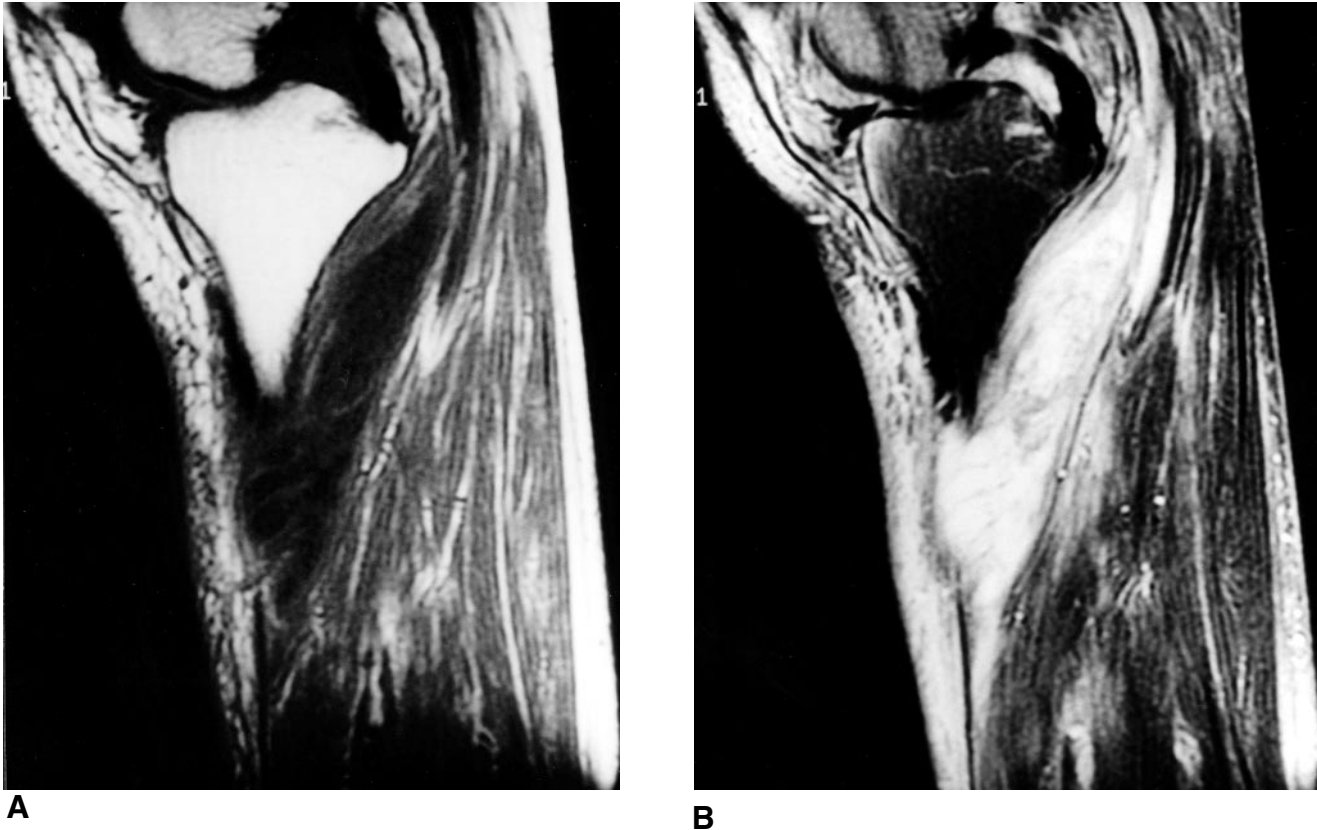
Sagittal MRI scans of the right leg after synovial rupture show wide areas of extravasated joint fluid in the gastrocnemius muscles extending to the anterior aspect of the tibia. The areas show hypointensity on T1 weighted images (A), and marked hyperintensity on T2 weighted fat suppression images (B).
